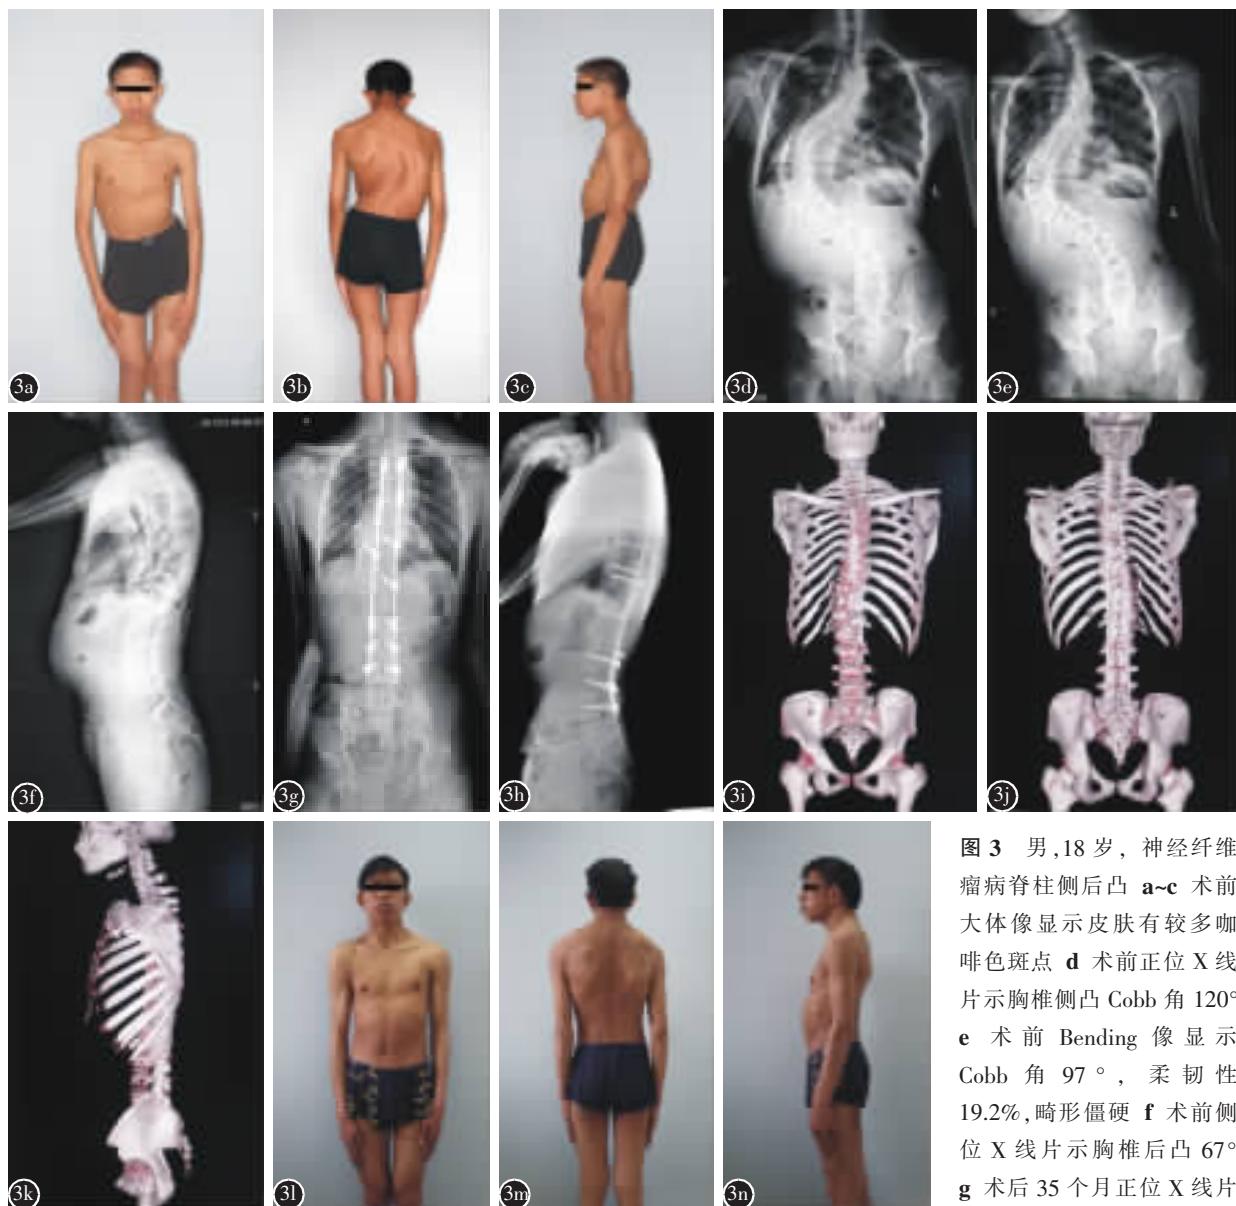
男,18岁,神经纤维瘤病脊柱侧后凸 a~c 术前大体像显示皮肤有较多咖啡色斑点 d 术前正位 X 线片示胸椎侧凸 Cobb 角 120° e 术前 Bending 像显示 Cobb 角 97°, 柔韧性 19.2%, 畸形僵硬 f 术前侧位 X 线片示胸椎后凸 67° g 术后 35 个月正位 X 线片示侧凸 Cobb 角 35°, 纠正率为 70.8% 和冠状面平衡 h 术后 35 个月侧位 X 线片示胸椎后凸 Cobb 角 25°, 后凸畸形矫正 i~k 术后 35 个月脊柱 3D-CT 显示新生肋骨形成, 胸廓无扭转 l~n 术后 35 个月大体像侧后凸矫正, 躯干平衡
